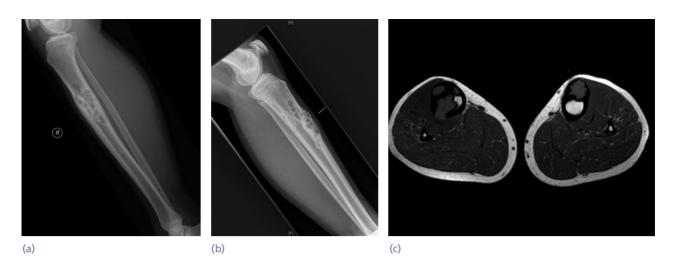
Osteofibrous dysplasia (OFD) A palpable mass over the anterior right tibia (a) of a 15-year-old boy who also complained of pain and a mass in the contralateral left tibia (b). MRI confirms bilateral osteofibrous dysplasia (c). Note the characteristic soap bubble ossification seen on plain X-ray and the narrow demarcation between the dysplastic regions and the native bone, without medullary invasion.
